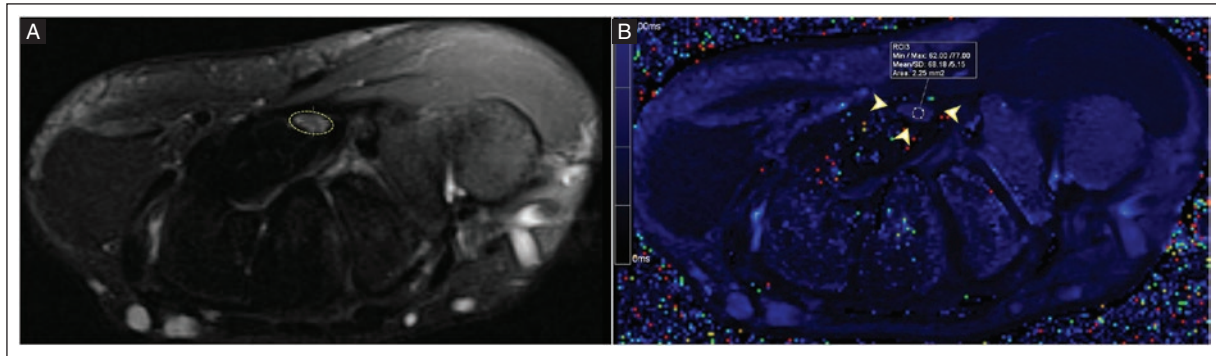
Axial MRI at the level of the carpal tunnel. A: T2 relaxometry multi-echo sequence (TR = 2400 ms; TE = 12 ms) shows homogeneous hyperintensity with normal appearance hypointense fascicles in the median nerve (yellow dashed circle). B: T2 relaxometry color map with a ROI of 2.25 mm² in the median nerve with a T2 relaxation time mean of 68.18 ms (yellow arrowheads).
